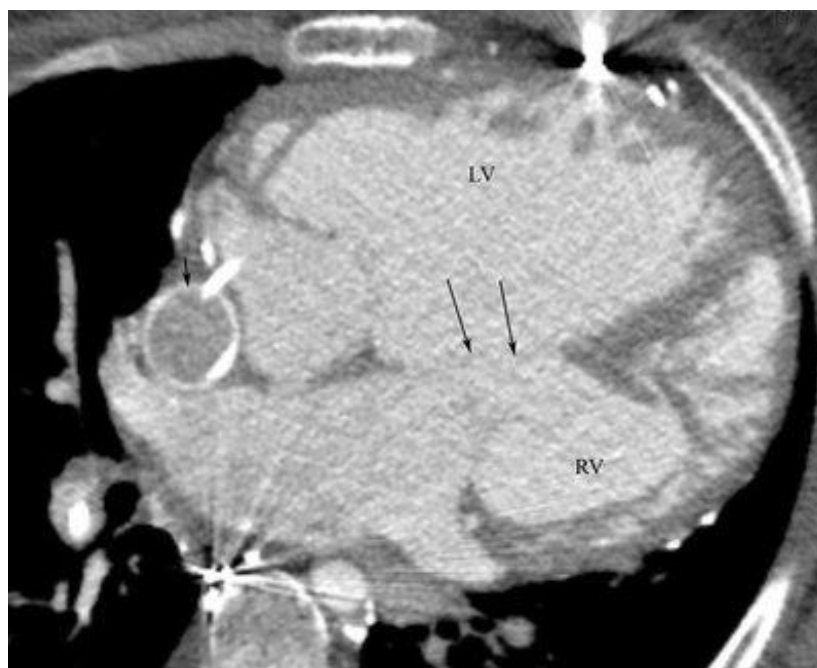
VSD affects a 21-year-old lady. In a patient with levo-transposition of the great arteries and substantial dilatation of the morphologic left ventricle (LV), which gives birth to the pulmonary artery, an axial contrast CT picture reveals a massive membranous VSD (long arrows). After the Fontan shunt revision failed, a PTFE graft (short arrow) was inserted lateral to the right atrium (RA) [18]
